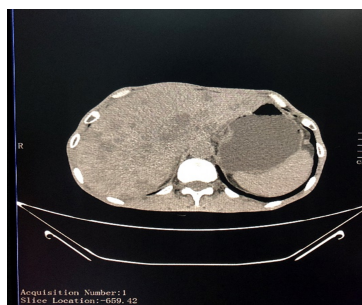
CT abdominal and pelvic enhancement: diffuse metastatic tumor foci in the liver, the number was significantly increased compared with before; multiple lymph nodes in the hepatogastric space and retroperitoneum were enlarged, metastasis was considered, and the pancreas was invaded; small amount of pelvic fluid was accumulated
